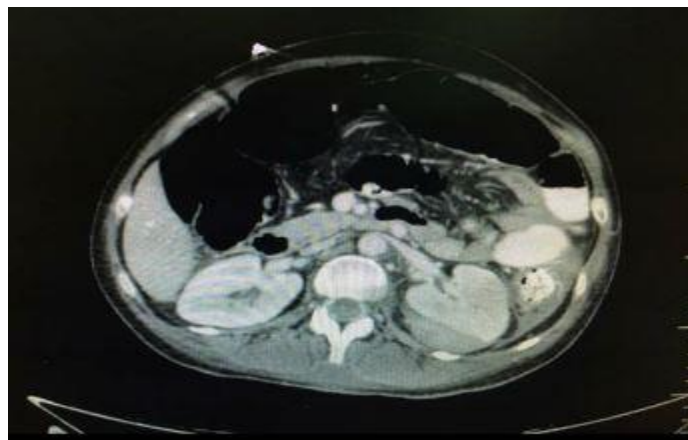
Kidney Abnormal CT scan
